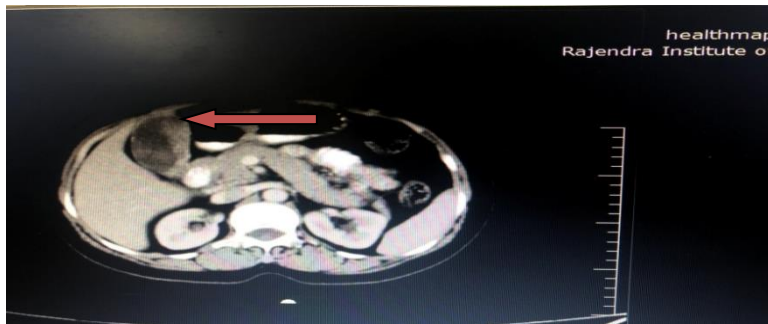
Intraluminal soft tissue density lesion (red arrow) enhancing on contrast CT. interface with liver preserved.
